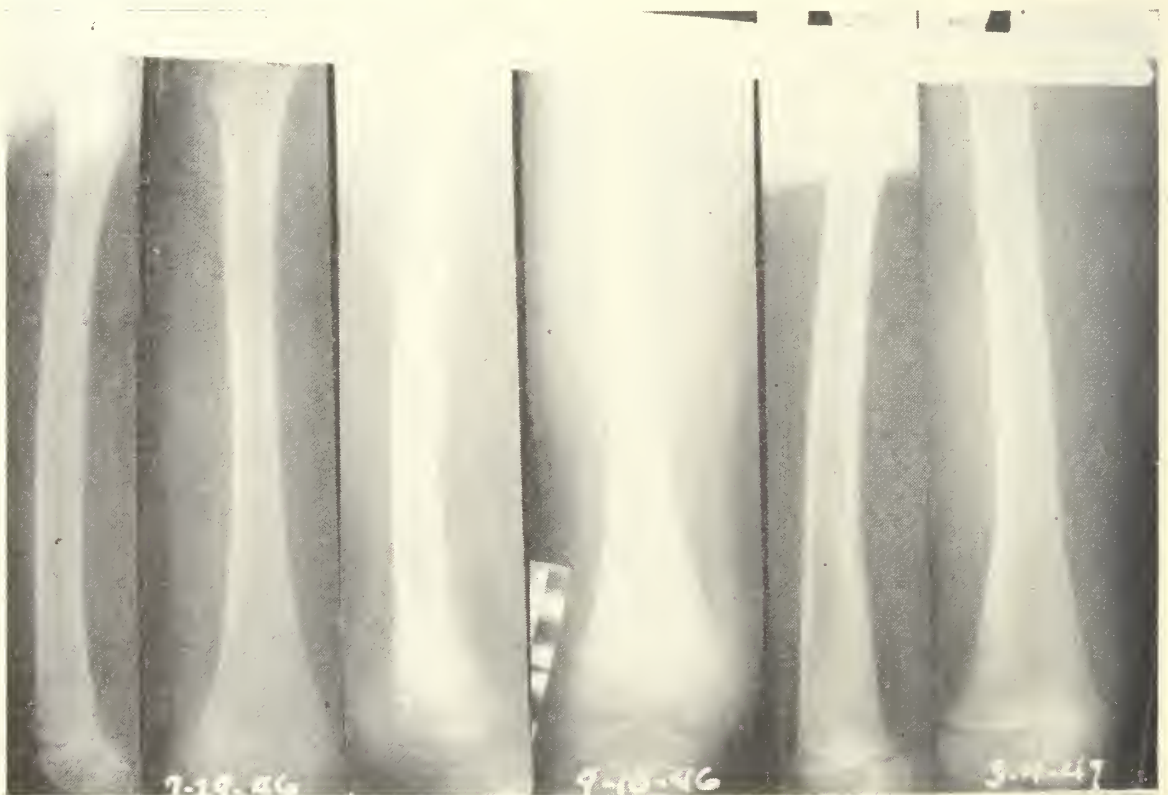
Case 2. Roentgenograms, July 29, 1946, September 10, 1946, and March 4, 1947. Nonoperative treatment of acute hematogenous osteomyelitis: Preliminary report. John J. Killefer, M.D., and Robert C. Robertson, M.D.
